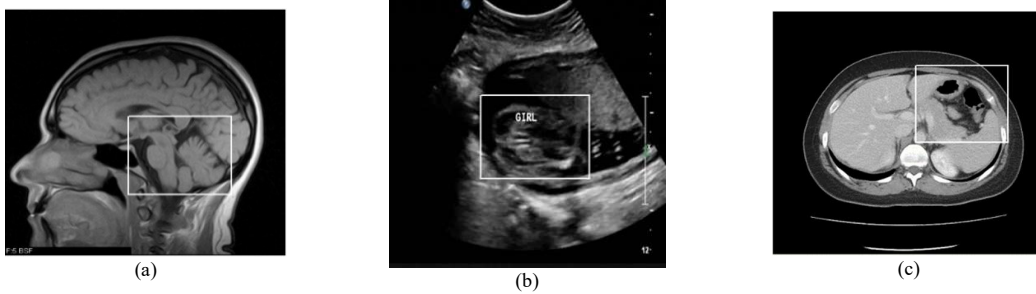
Cover images: (a) MRI of brain (b) Ultrasound of uterus (c) CT of liver
